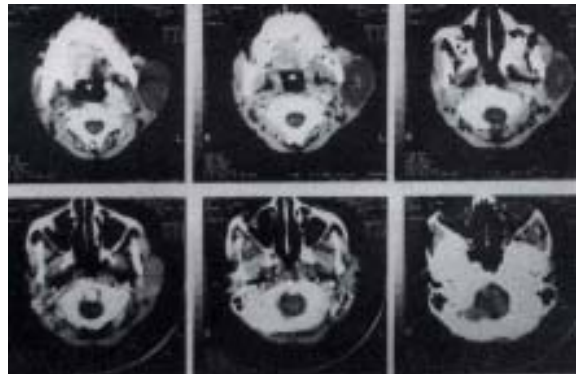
CT scan showing the cystic cavity and its boundaries
